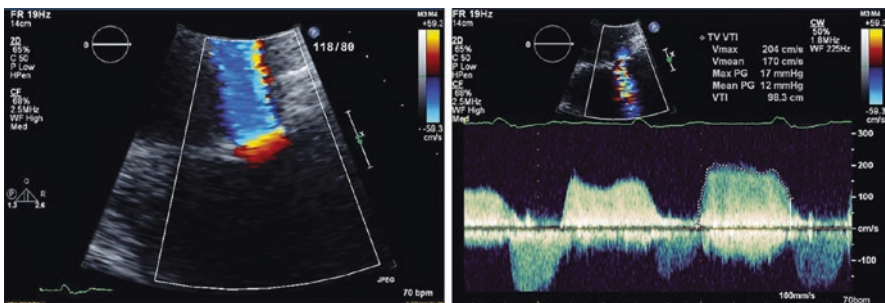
Prosthetic tricuspid stenosis. Left: Zoomed apical four-chamber TTE view showing color flow acceleration across a 3-mm St. Jude tricuspid prosthetic valve during diastole, consistent with tricuspid stenosis (Video 5.5). Right: Transtricuspid prosthetic gradient shows a peak velocity of >2 m/s and a mean gradient of 12 mmHg, suggesting severe prosthetic stenosis
